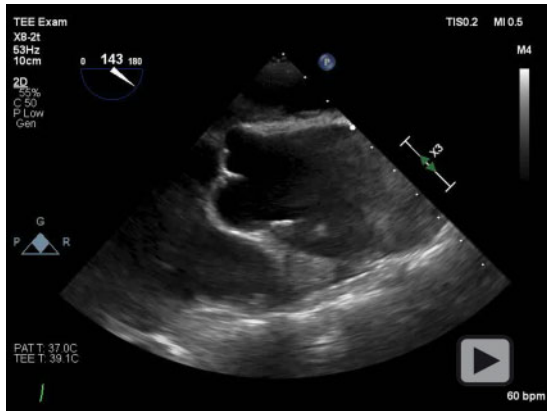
(A) Transoesophageal echocardiography showed no abnormal finding of the ascending aorta at 3 min after probe insertion. (B) Transoesophageal echocardiography demonstrated ascending aortic dissection (white arrows) at 5 min after probe insertion.
